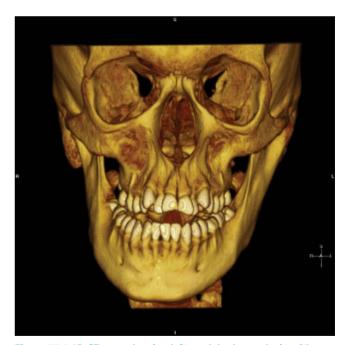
3D-CT scan showing left condylar hyperplasia with centreline deviation and lengthening of left ramus.
